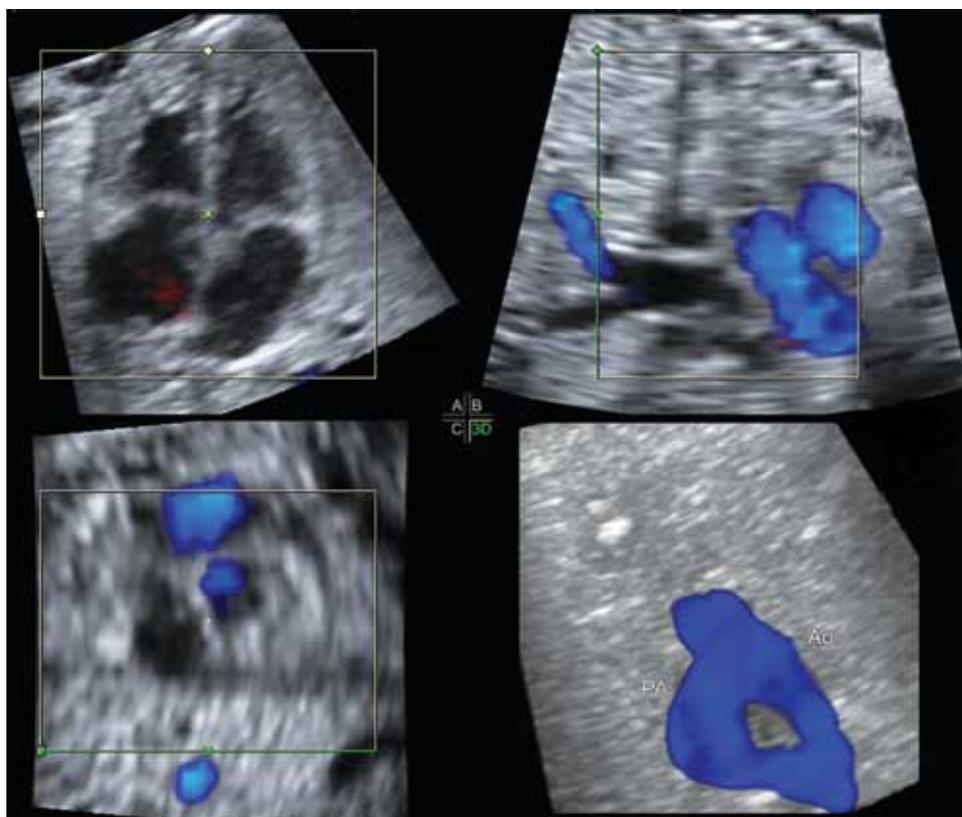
Technique for obtaining the crossing of the great vessels using color Doppler with spatiotemporal image correlation: the volume capture should be performed with this feature on; later, the region of interest (ROI, green line) positioned in plane B is selected in the anterior to posterior direction (from the pulmonary artery to the aorta and ventricles). The rendered image will then show the crossing of the great vessels of the base (Ao: Aorta; PA: Pulmonary artery)
